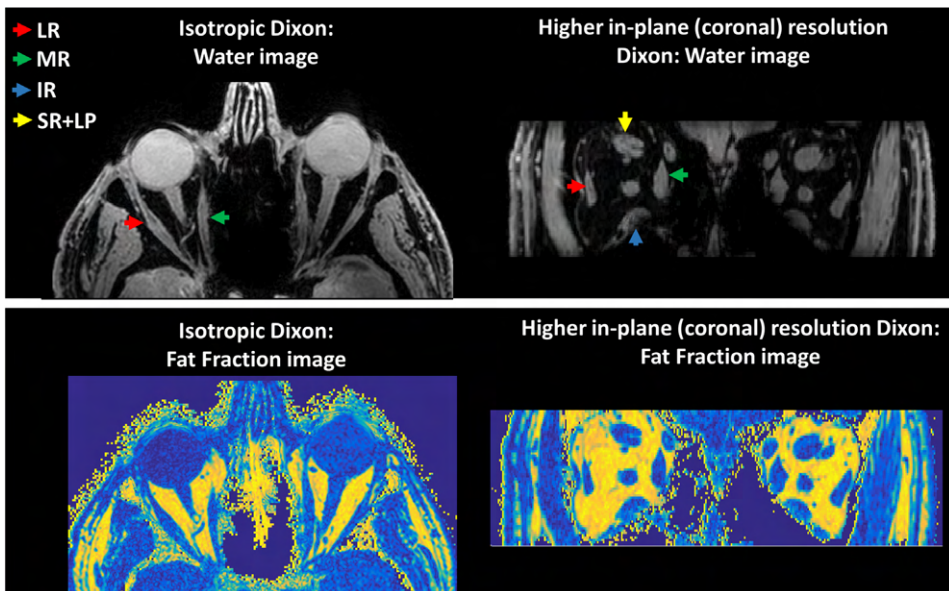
Examples of water images on top and fat fraction maps below as measured with a chemical shift based water fat separation gradient echo MRI-scan. The colored arrows point out the lateral rectus muscle (LR; red), the medial rectus muscle (MR; green), the inferior rectus muscle (IR; blue) and the superior rectus and levator palpebrae muscle complex (SR+LP; yellow). Adapted from Keene KR et al. The feasibility of quantitative MRI of extra-ocular muscles in myasthenia gravis and Graves' orbitopathy. *NMR Biomed* 2021;34:e4407.
